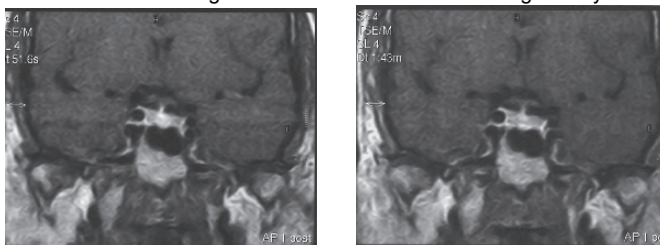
Magnetic resonance imaging showing the 5-mm maximal diameter microprolactinoma located in the left portion of the gland (arrow) at diagnosis (top) and its disappearance after 12 months of cabergoline treatment (bottom)
